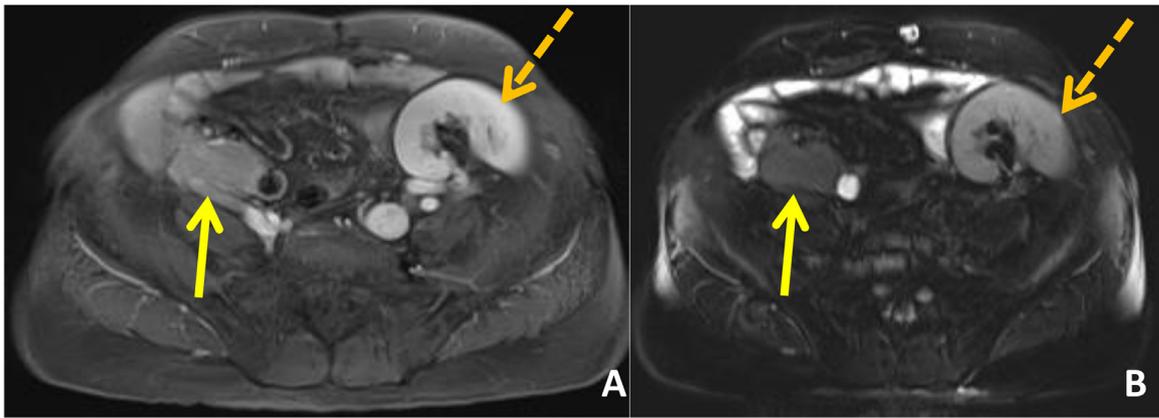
T1-weighted post-contrast (A) and T2 weighted (B) fat-suppressed images of a 58-year-old male status post Simultaneous Pancreas and Kidney transplants demonstrating normal appearing pancreas (solid arrow) and kidney (dashed arrow) transplants. Pancreas transplants are hyperintense on T1 and hypointense to fluid, but hyperintense to muscle on T2. (Color version of figure is available online.)
